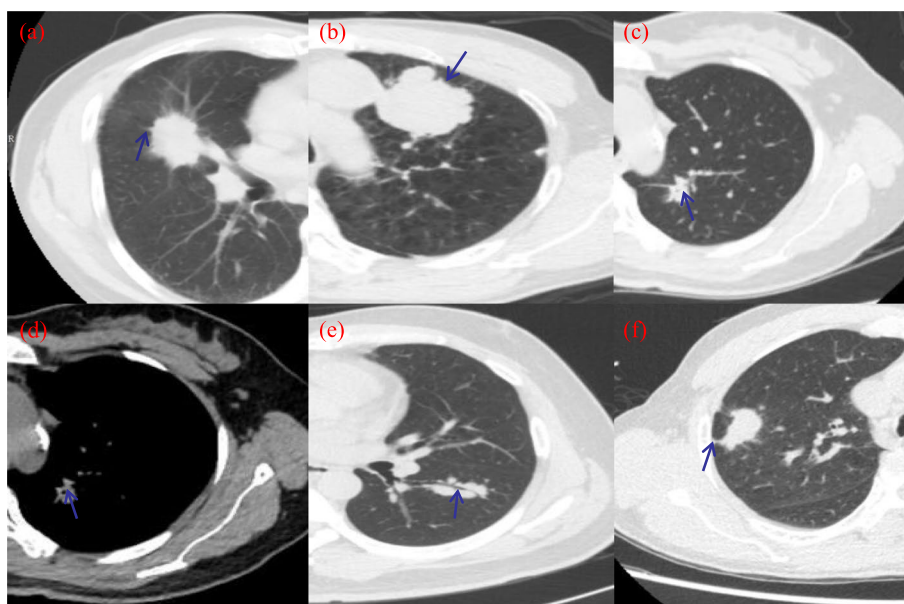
Representative computed tomography images showed morphological features of lung adenocarcinoma. Spiculation (a), lobulation (b), vacuole sign (c, d), air bronchogram (e), and pleural indentation (f) (shown as arrows)
